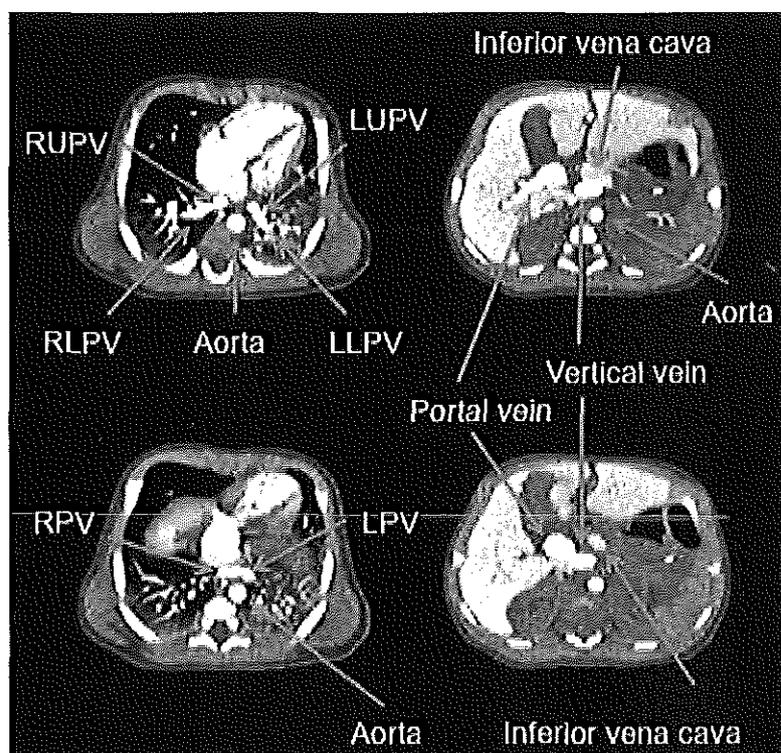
Infra-cardiac type total anomalous pulmonary venous return assessed by 320-row MDCT using MPR. A common PV trunk is formed by the RUPV, RLPV, LUPV and LLPV. Vertical vein runs caudally and connects to portal vein. LLPV, left lower pulmonary vein; LPV, left pulmonary vein; LUPV, left upper pulmonary vein; MDCT, multi-detector row computed tomography; MPR, multiplanar reformation; RLPV, right lower pulmonary vein; RPV, right pulmonary vein; RUPV, right upper pulmonary vein.
